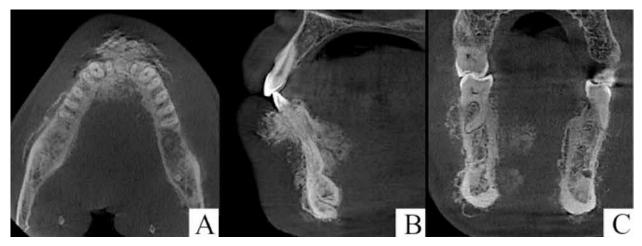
(A) Axial, (B) sagittal and (C) coronal CBCT images
